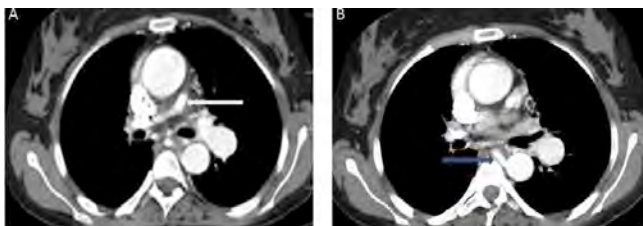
Computed tomography angiography of the chest revealed atresia of right and almost agenesis of left pulmonary artery and aortopulmonary collateral artery (arrows).
